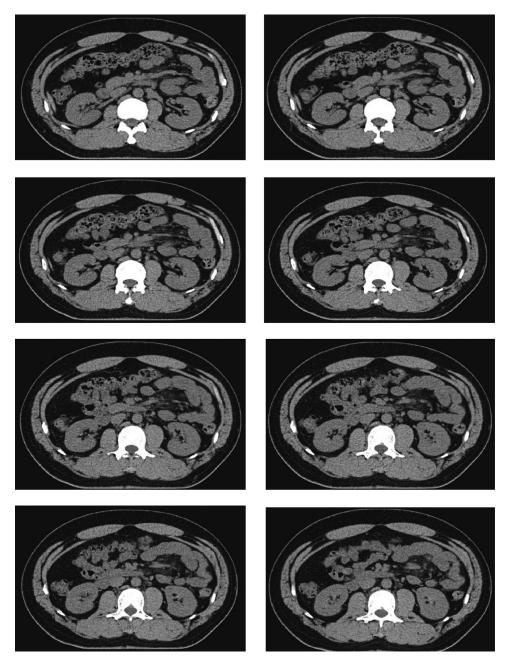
Abdominal CT image showing relieved densification of the mesenteric fat and thickened subcutaneous fat after half a year.
